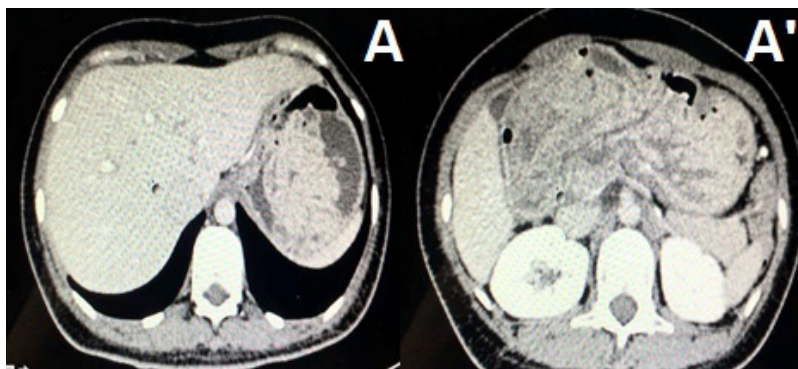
CT of the abdomen with venous contrast, showing a large coralliform lesion of 16.3 x 10.2 x 5.4 cm in the stomach (A) and in the first duodenal part (A')
